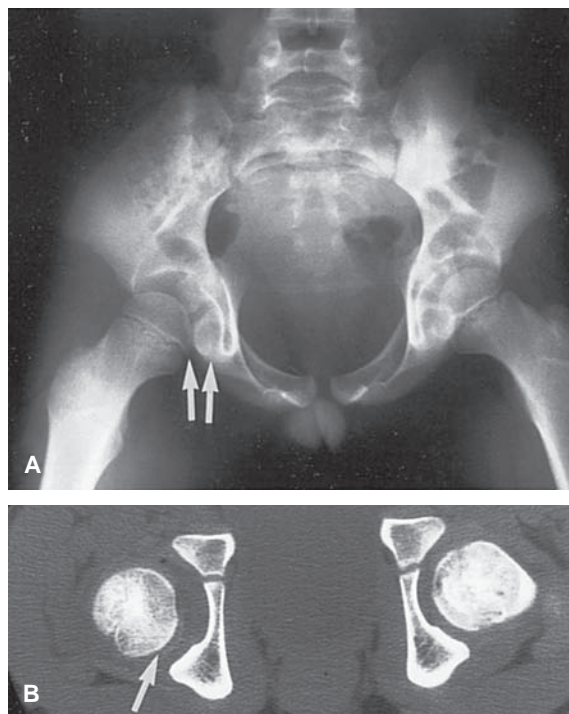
Radiographs taken following closed reduction of a right hip dislocation. A: The plain film demonstrates residual widening of the joint space (*arrows*). B: Widening is also apparent with magnetic resonance imaging, as is entrapment of a portion of the posterior joint capsule. Under general anesthesia, further efforts at closed reduction were successful.
